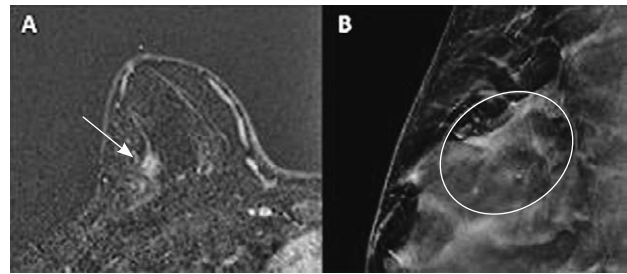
(A) Axial subtraction image of the right breast showing an oval mass (arrow) and an area of non-mass enhancement in the posterior region (asterisk), representing an extensive intraductal component. (B) Calcification on the mediolateral oblique projection of the right breast (circle), but the extent is better seen with MRI. Final pathologic examination revealed a luminal B, HER-2 positive breast carcinoma pT1c pN0 (ER 100 %, PR 90 %, Ki67 15 %) with an in situ component
